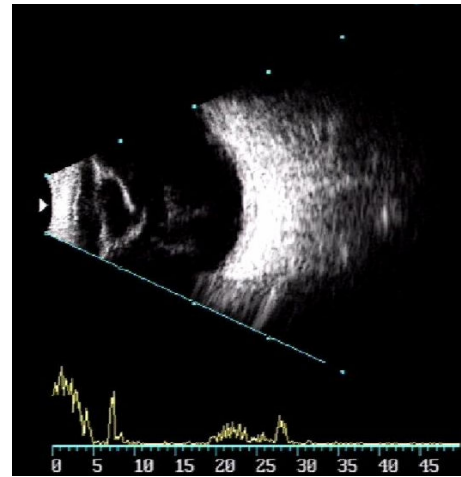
A and B scan ultrasound of open globe injury
